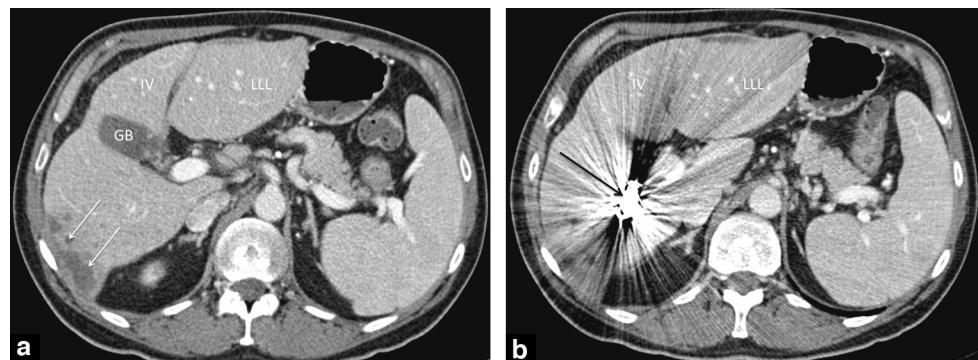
Axial portal venous phase CT obtained 23 days after portal vein embolization. IV, I, LLL and GB correspond to segment IV, I, the left liver lobe and the gallbladder respectively. Image (a) is obtained at the same plane as Fig. 3. White arrows (a) correspond to distal infarcts in the sub capsular part of the right liver lobe. Black arrow (b) corresponds to post-portal vein embolization coils.
